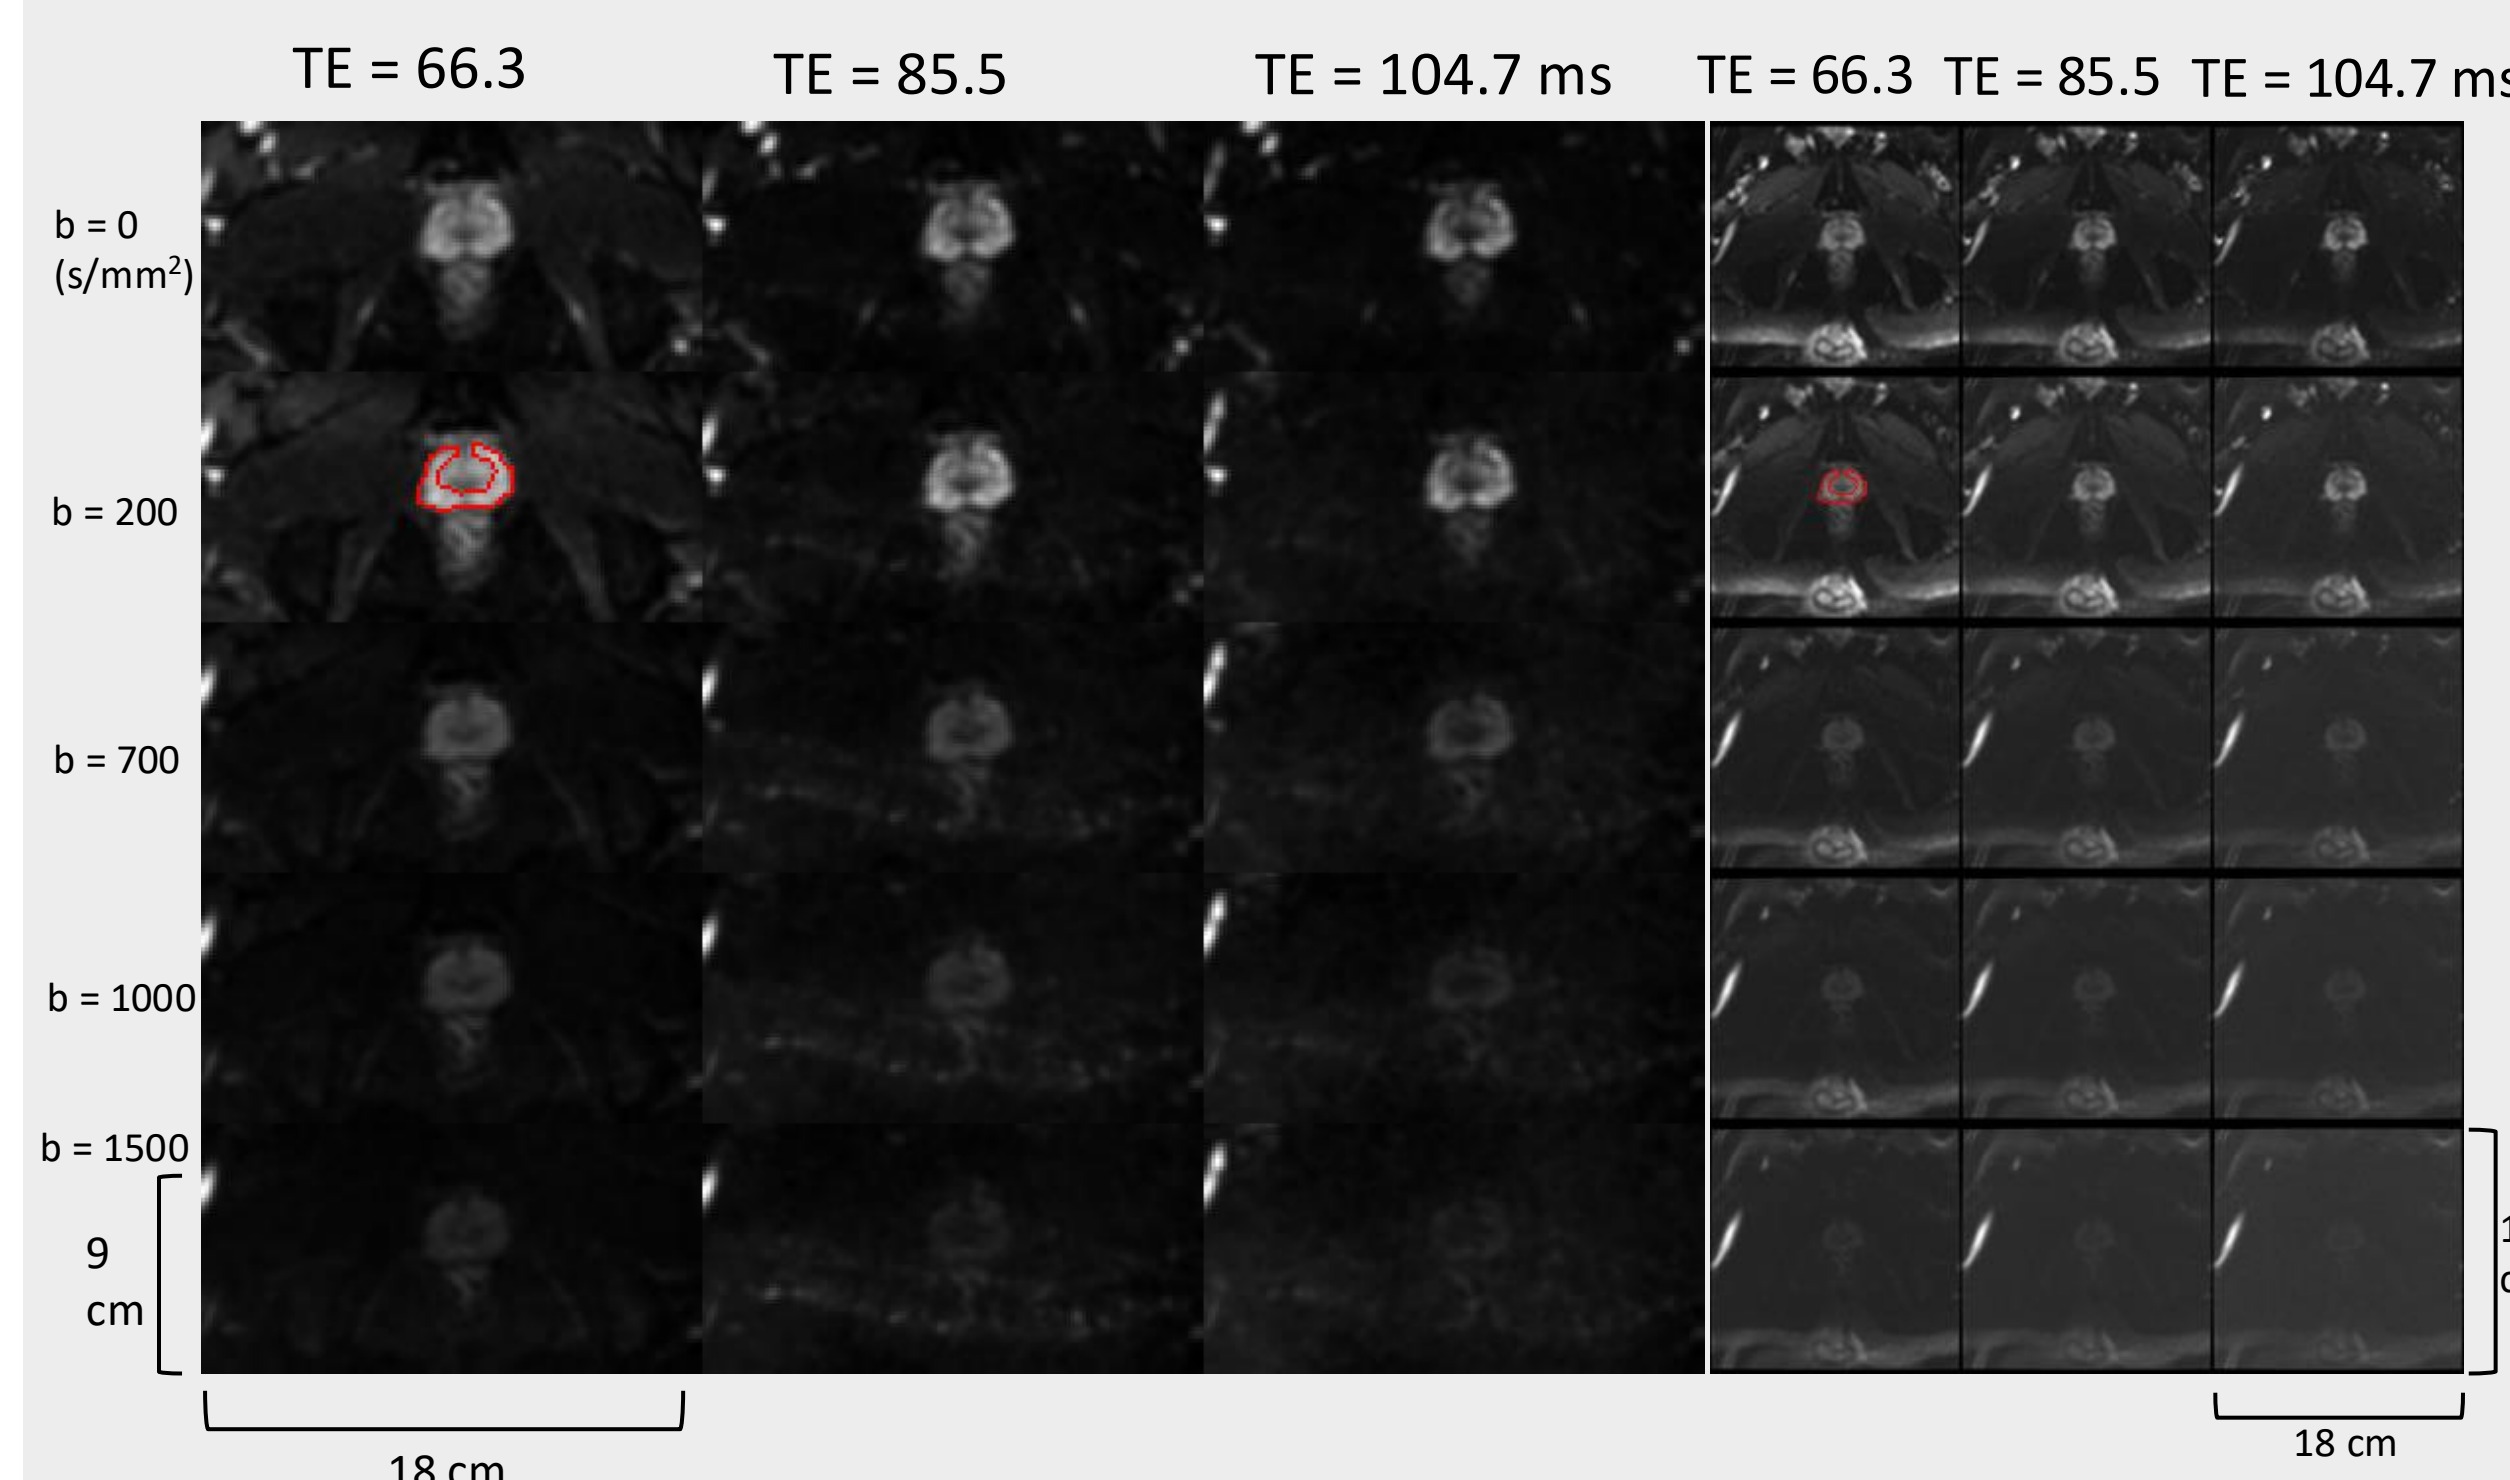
Multi-echo DWI images of the prostate acquired from a 40-year-old healthy male subject using the MR-MED sequence (left) and the conventional sequence (right). A region of interest (ROI) is drawn on the images with b = 200 s/mm² and TE = 66.3 ms.
